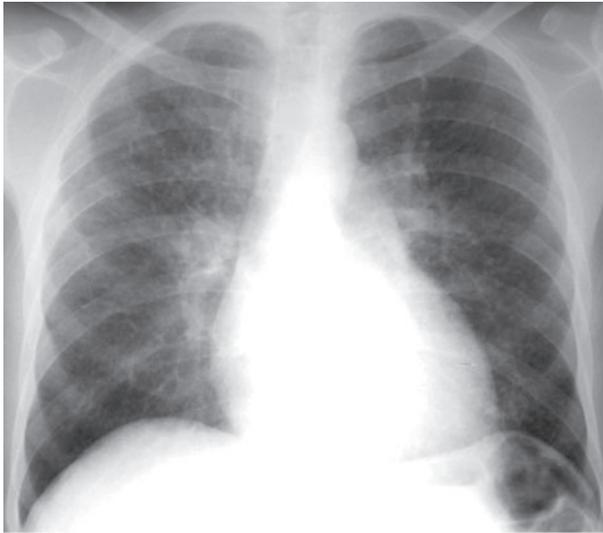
Silicotuberculosis in a crack cocaine smoker. (a) Chest radiograph shows bilateral, relatively symmetric parahilar masses (arrows). (b) CT scan better characterizes the masses.
